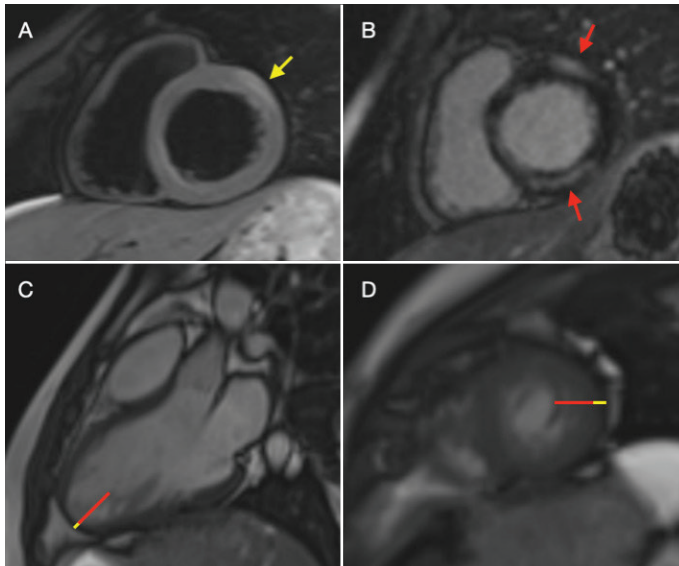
CMR in a 23-year-old male patient with a preliminary diagnosis of myocarditis due to chest pain, elevated troponin levels, and ventricular dysfunction following viral infection. The Updated Lake Louise criteria confirmed acute myocarditis. (A) T2-weighted image showing edema (yellow arrow) in the basal anterolateral wall. (B) T1-weighted image revealing nonischemic late gadolinium enhancement (red arrow) in the basal anterolateral, inferior, and inferolateral walls, consistent with myocarditis. (C) Cine images on long-axis 4-chamber view at end-diastole, demonstrating $NC/C > 2.3$ (Petersen criterion), (D) Cine images on short-axis view at end-systole, indicating $NC/C \geq 2$ (Stacey criterion) hypertrabeculation. The yellow line represents the compacted layer, and the red line represents the noncompact layer.
